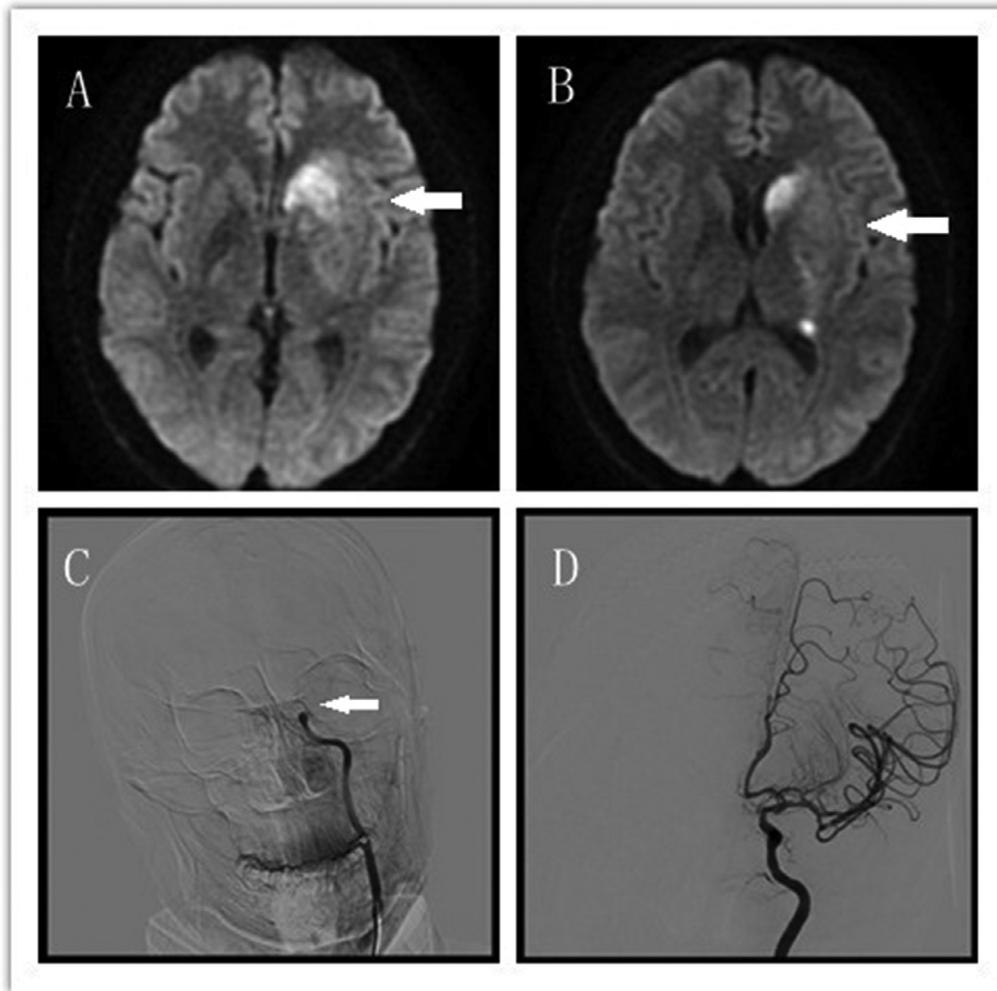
Cerebral embolism in the region of the left middle cerebral artery. (A) MRI DWI ischemic focus in the basal ganglia region. (B) MRI DWI ischemic focus in the basal ganglia region. (C) Cerebral angiography displayed a left middle cerebral artery that was interrupted in the middle of the horizontal part, whereas the distal artery was not displayed (arrow). (D) Cerebral angiography displayed the entire left middle cerebral artery after endovascular removal of the thrombus by the Penumbra System Angiography.
